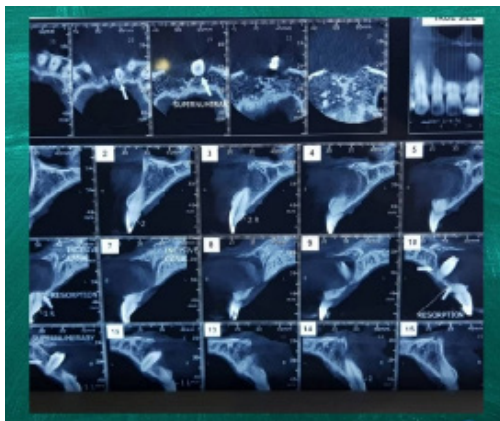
Computed tomography (CT) scan, in axial and coronal section showed a large unilocular lesion with crown of mesiodens in the anterior maxilla.
